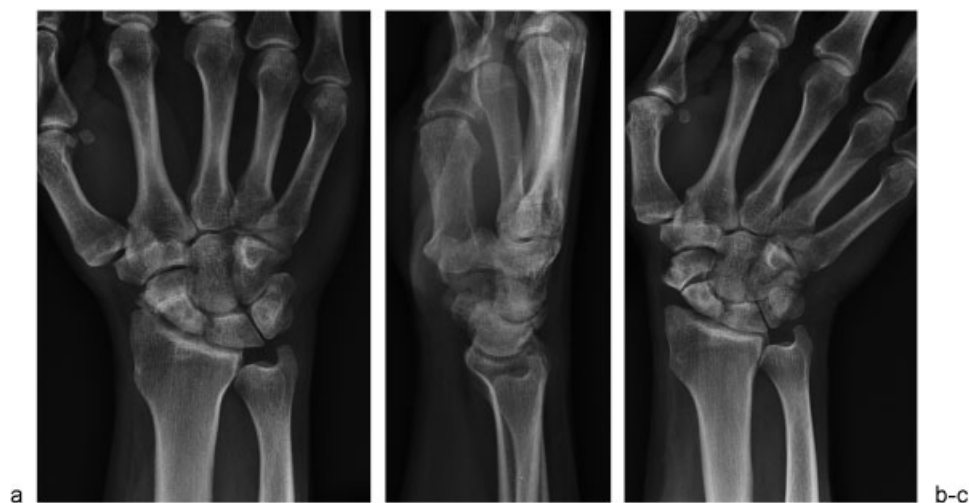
(a) Anteroposterior (b) and lateral preoperative radiographs showing scaphoid nonunion with carpal collapse and mild cystic changes. (c) Ulnar deviation view demonstrating large defect in the scaphoid.
